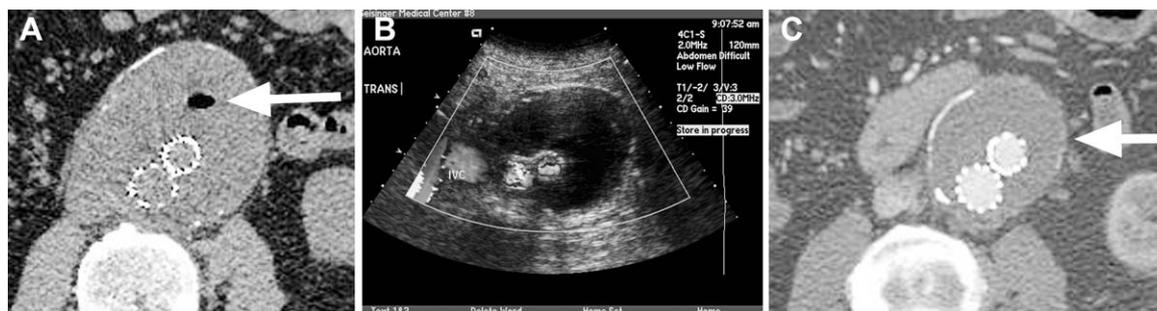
♦ (A) Non-contrast CT scan 1 month after surgery demonstrating a small residual collection of trapped gas anteriorly within the thrombus of the sac (arrow). (B) Duplex scan at 1 month after surgery demonstrating a patent aortic stent-graft without flow in the sac. (C) Contrast-enhanced CT scan at 13 months demonstrating patent graft limbs, no evidence of endoleak, resolution of the anterior gas pocket, and a significant decrease in sac size (arrow).
